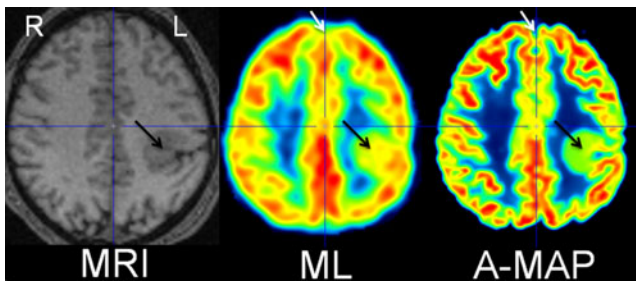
T1, ML and A-MAP reconstructed FDG-PET images from a patient with FCD in the left parietal cortex (patient 2) (*black arrows*). ML FDG-PET images show hypometabolism in the medial frontal cortex bilaterally (*white arrow*). This hypometabolism is not seen on A-MAP reconstructed FDG-PET images (*white arrow*), suggesting its false-positive character. Images are coregistered
